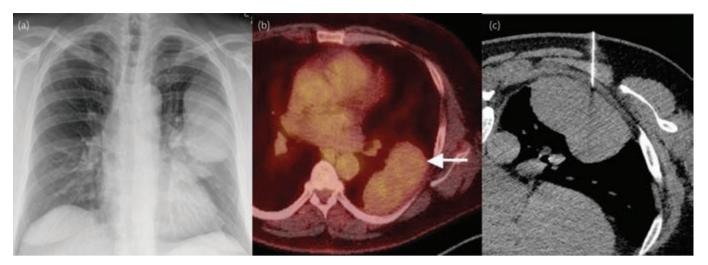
Solitary fibrous tumour. The chest radiograph (a) of a 56-year-old man with a persistent cough shows a large lobulated opacity in the left hemithorax. Computed tomography (CT) and positron emission tomography (b) showed a 10.8 cm solid pleural-based mass (arrow) with heterogeneous low-grade fluorine-18 fluorodeoxyglucose (FDG) uptake, involving the left lower lobe and invading across the oblique fissure to involve the left upper lobe. CT-guided core biopsy of the mass (c) showed features consistent with a solitary fibrous tumour, which was subsequently resected.
